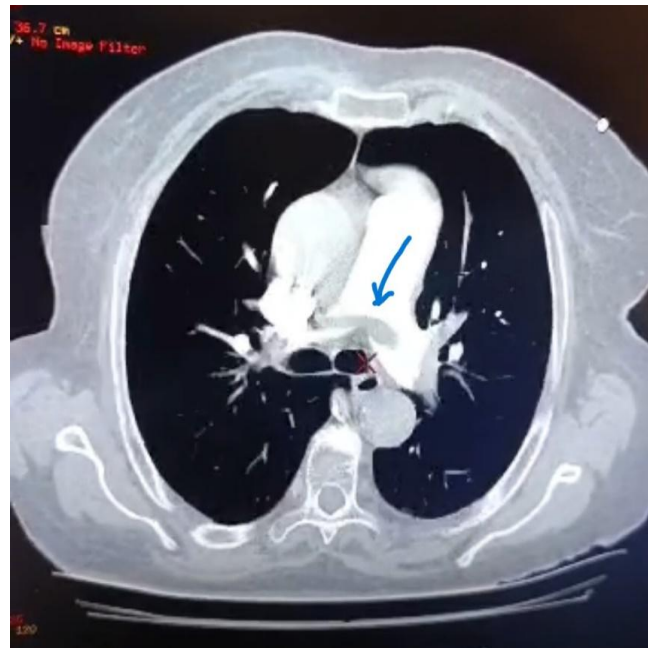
CT pulmonary angiography demonstrating a large saddle pulmonary embolism involving the main pulmonary arteries (arrow)
